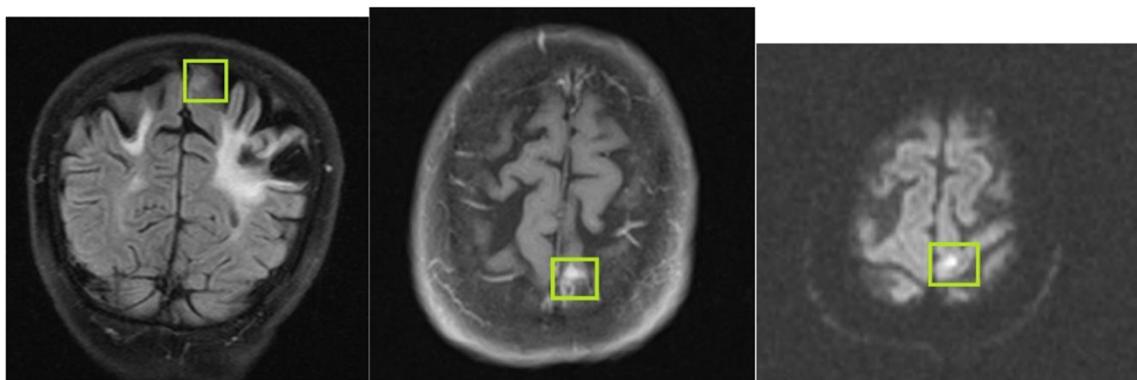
FLAIR protocol and T1 postcontrast images shows the infarction area marked with green frame, respectively. Diffusion weighted MRI also shows restriction of diffusion in the rightmost image. All of these findings
